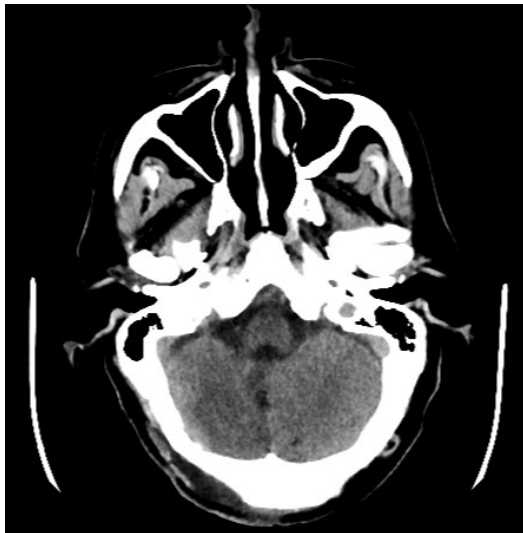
Native axial cranial CT scan. Postoperative condition. Decompressed IV ventricle (red arrow)
